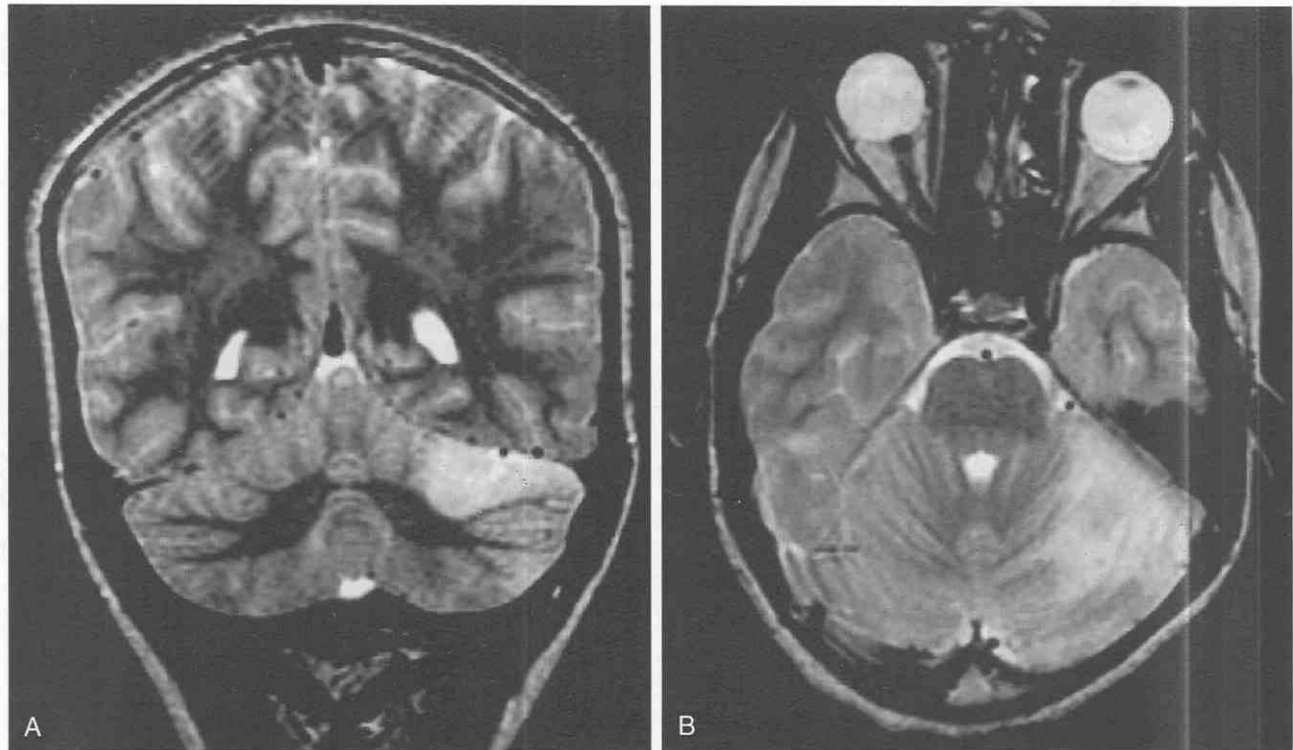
Ataxia in an 8-year-old girl. *A*, Coronal T2-weighted MR image shows a wedge-shaped area of increased signal in the superior left cerebellar hemisphere. *B*, Axial T2-weighted image confirms abnormality in the territory of the superior cerebellar artery. Biopsy showed evidence of evolving infarction.
